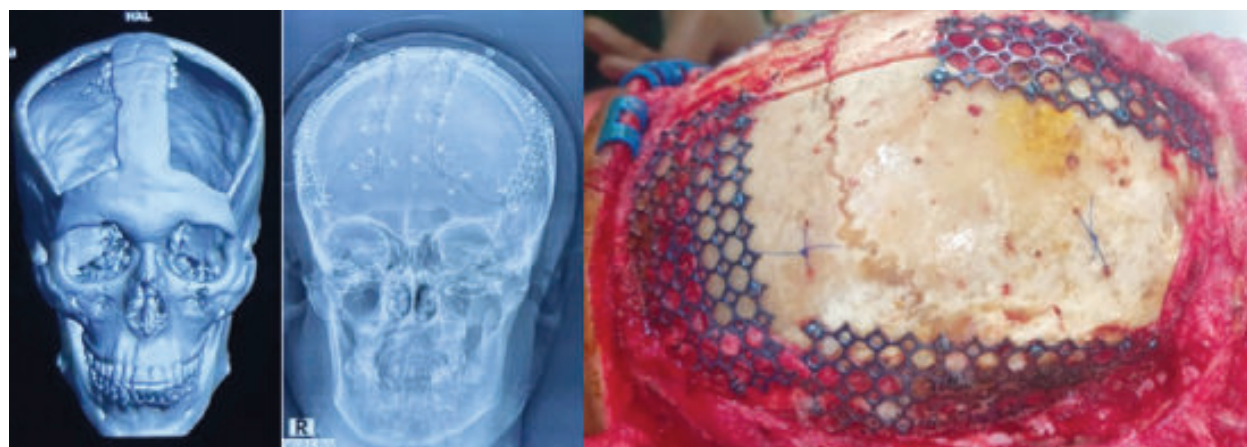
Pre-Operative CT scan showing bone gap of bilateral craniectomy (left), Post operative X-Ray Skull showing accurate placement of bone graft (middle) per-operative image of cranioplasty of a different patient showing bone gap and burr hole gap covered sufficiently with titanium mesh plate.
